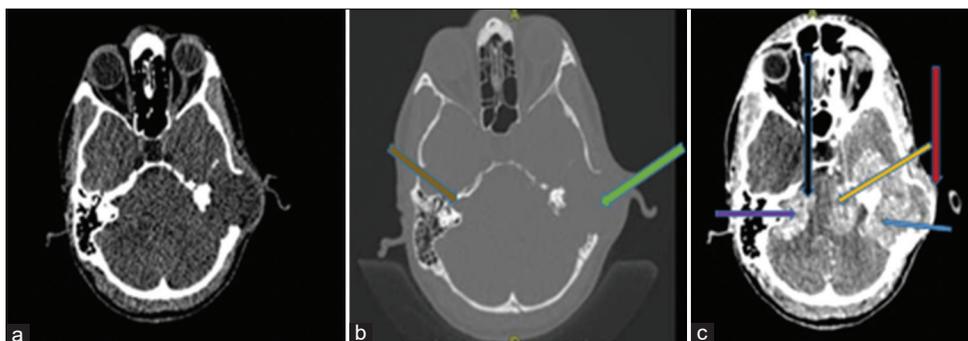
(a) Axial section of NECT brain, (b) axial sections of HRCT temporal bone, and (c) axial section of CECT brain showing bilateral vestibular schwannoma. Well-defined extra-axial heterogeneously hypodense intensely enhancing lesions noted in left CP angle cistern causing widening of the left IAC (blue arrow) extending medially and causing compression of pons and medulla (yellow arrow), laterally extending into mastoid air cells up to subcutaneous planes and displacing the pinna (red arrow), the lesion is causing widening and erosion of left temporal bone involving IAC, petrous apex, mastoid air cells, left middle ear cavity including malleus, incus, stapes, and the external auditory canal (green arrow). A similar lesion in the right CP angle cistern (purple arrow) causing widening of rt internal auditory meatus (brown arrow), extending medially and compressing pons, medulla, and abutting right cerebellar hemisphere (black arrow)
